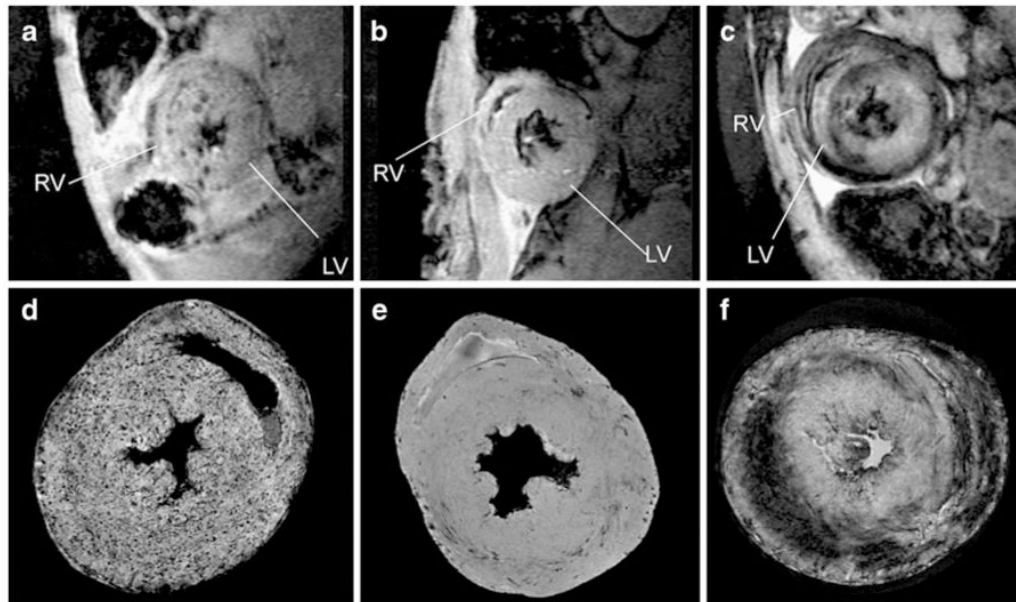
Contrast patterns with different contrast agent labeling. a–c, In vivo MRI of macrophage accumulation on POD 6 of a an allograft heart with MPIO-particle labeling; b an isograft heart with MPIO-particle labeling; and c an allograft heart with USPIO labeling, with 156 μm in-plane resolution at 4.7-Tesla d–f. MRM at 11.7-Tesla Bruker AVANCE-DBX MRI instrument with in-plane resolution of 40 μm of d an allograft heart with MPIO-particle labeling; e an isograft heart; and f an allograft heart with USPIO labeling. LV—left ventricle; RV—right ventricle. (From Wu et al. [25•]; with permission)
